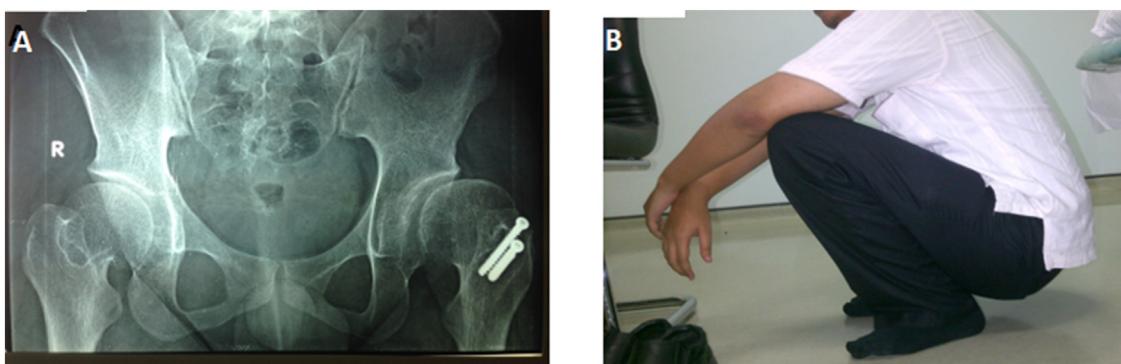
(A) 20 months postoperative hip x-ray: the dysplastic femoral head was fixed with two screws appeared intact with no recurrence; (B) The patient was able to squat without pain.
